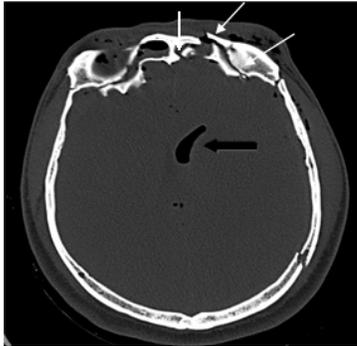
CT Axial section (brain window) at the level of frontal sinuses showing multiple craniofacial fractures involving frontal sinuses, diffuse cerebral edema (▶), subdural hemorrhage (⇒), and subarachnoid and intraventricular pneumocephalus (←)
